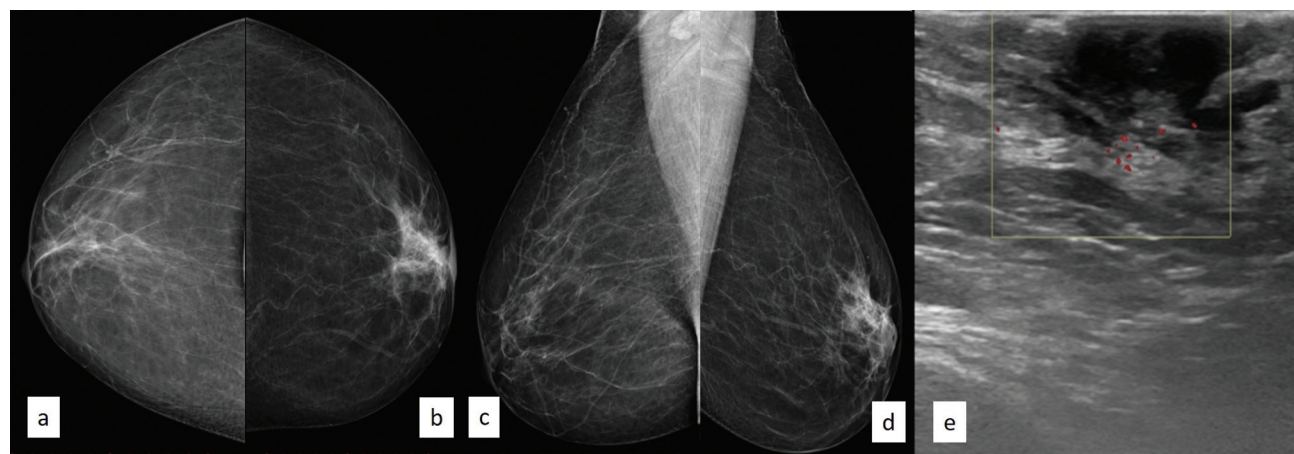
A 60-year-old woman with granulomatous mastitis of the left breast. (b) Craniocaudal and (d) mediolateral Mammography views shows the presence of architectural distortion and focal asymmetry in the retroareolar region of the left breast. (e) Ultrasound shows hypoechoic lesion in the retroareolar region without any significant vascularity. (a) Craniocaudal and (c) mediolateral Mammography views of right breast show normal breast parenchyma.
